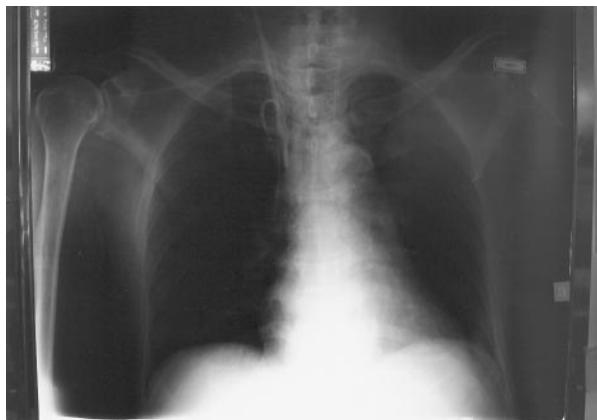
Chest radiograph showing the acute angulation of the PAC in the right IJV at the end of the sheath.
